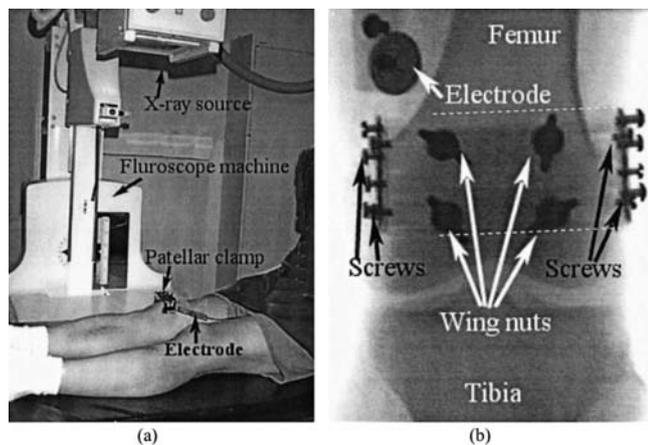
Fluoroscopic imaging experimental setup used to check the consistency between the patella and patellar clamp in patellar tracking induced by electrical stimulation of an individual quadriceps component. a. Setup; b. a corresponding posterior view of the right knee, mounted patellar clamp, and stimulation electrode. The dotted line shows the approximate position of the patellar clamp, which was made of aluminum and was not clearly shown under x-ray.
